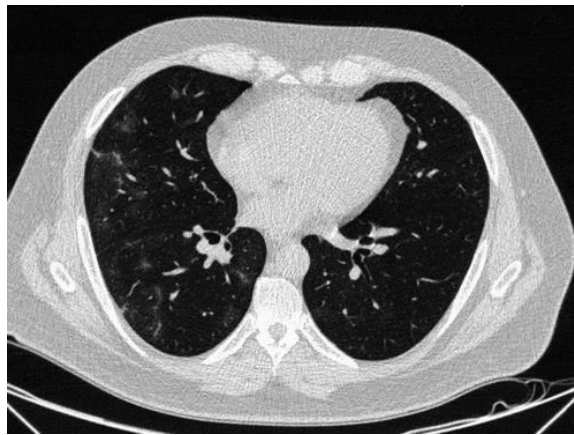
Axial CT image 10 days later shows improvement in previously noted lung infiltrates.
